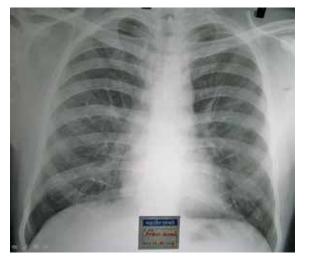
Chest x-ray of case 1, depicting clear lung fields, when he had haemoptysis
